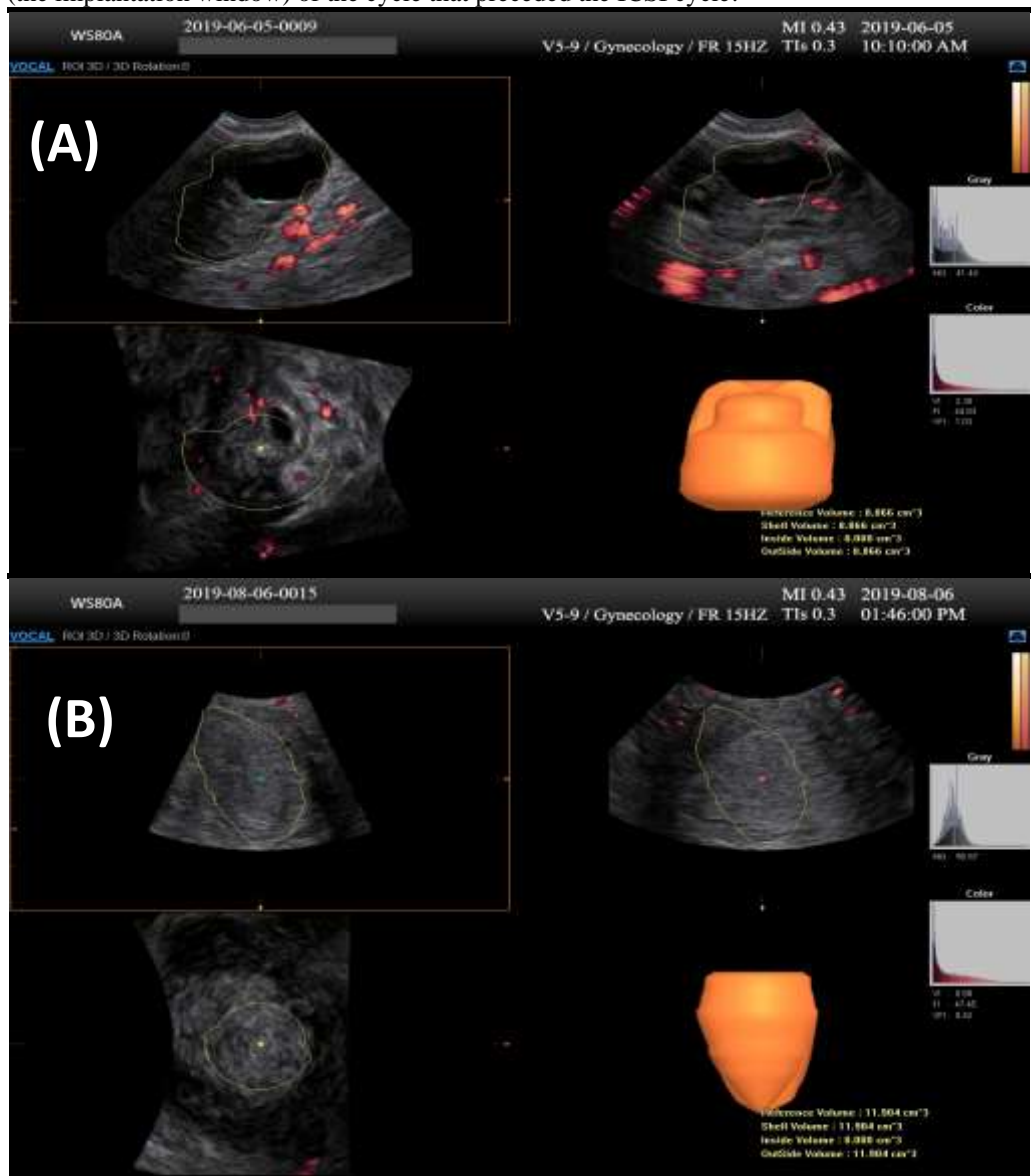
Figure Error! No text of specified style in document.-3: VOCAL imaging (volume and 3D power Doppler indices).
